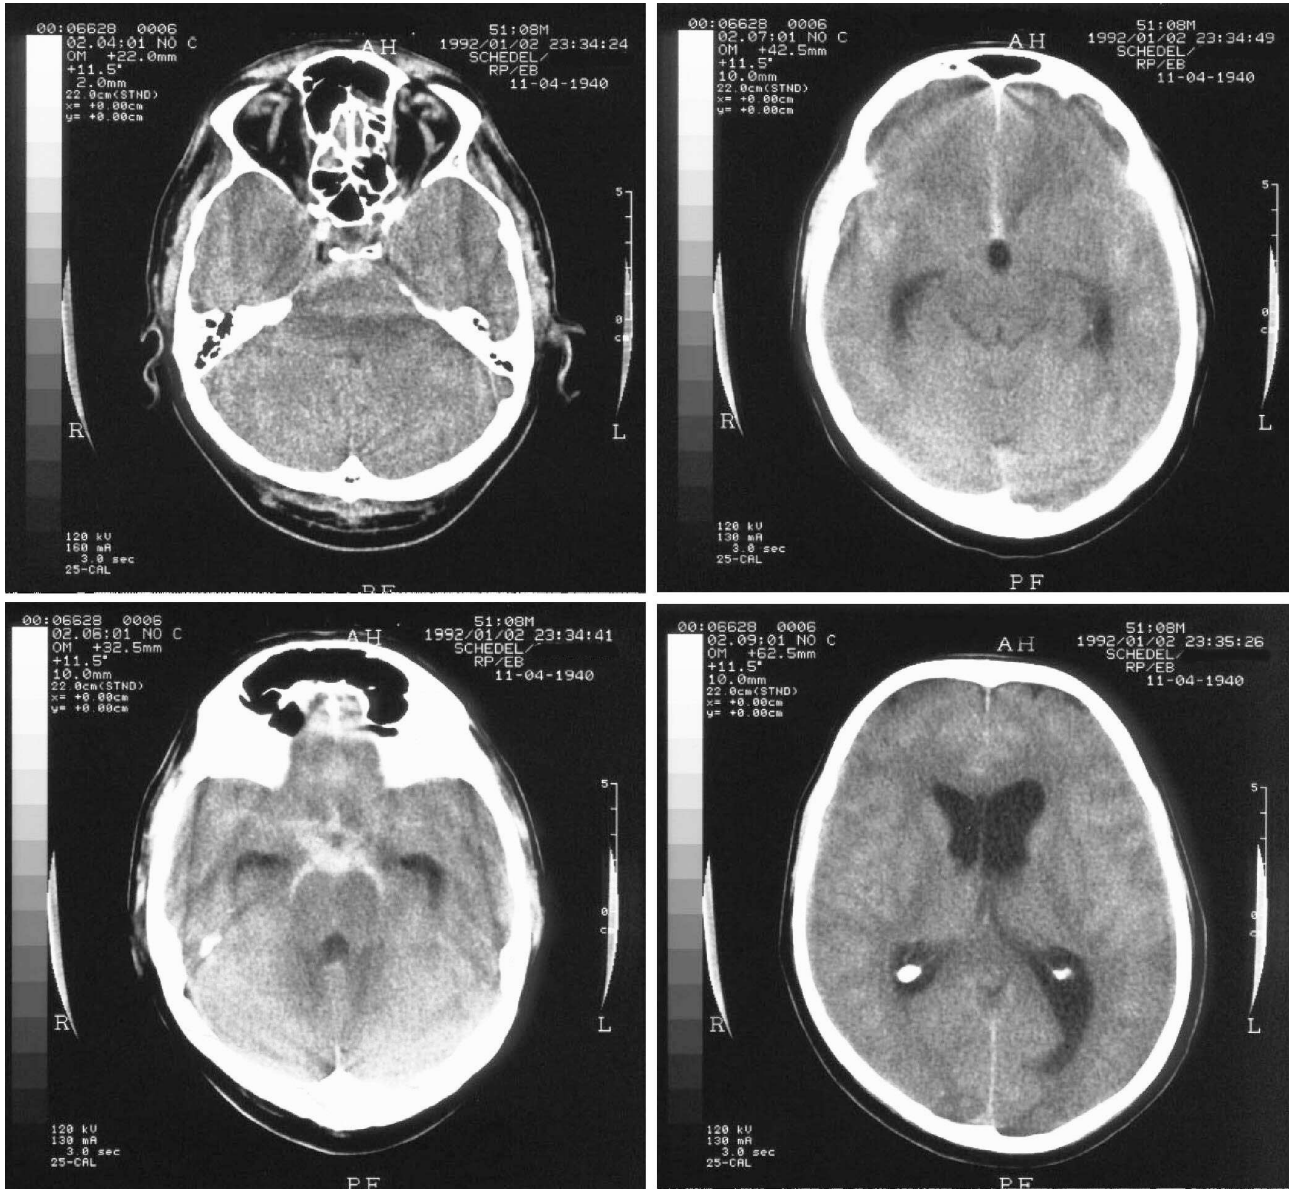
The computed tomogram of a patient with a ruptured aneurysm of the internal carotid artery at the origin of the right posterior communicating artery on the angiogram. In this patient, rater 1 predicted a ruptured aneurysm of the anterior communicating artery and rater 2 predicted a ruptured aneurysm of the basilar artery
